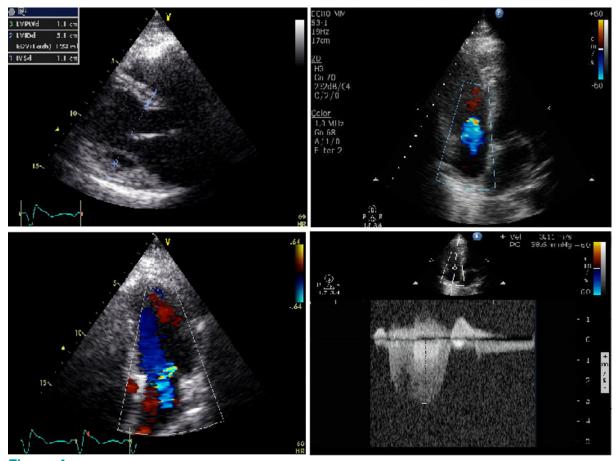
Echocardiography demonstrating preserved left ventricle systolic function with mild hypertrophy, mild mitral regurgitation, mild to moderate tricuspid regurgitation, and mild to moderate pulmonary hypertension.
